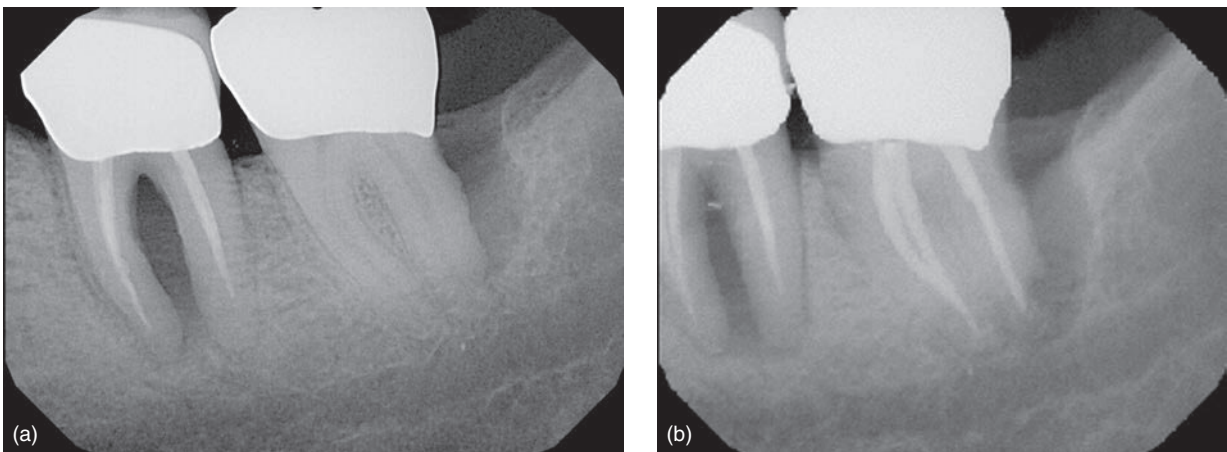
Mandibular second molar with combined periodontal and endodontic lesions. Diagnostic tests showed pulp necrosis. (a) Radiograph showing extent of distal bone loss. (b) After endodontic treatment, bony defect and periodontal probing did not improve, indicating that the defect was primarily due to periodontal disease.
